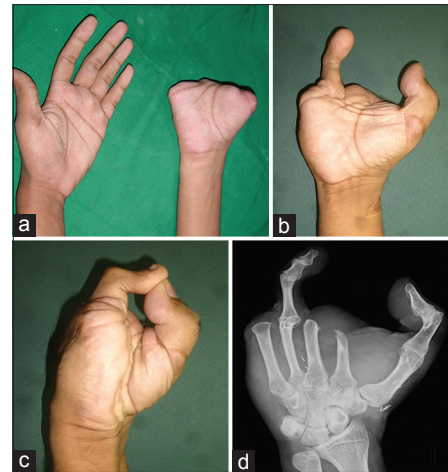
Patient 5, type 2A metacarpal hand. (a) Both hands, prior to toe transfer. (b) Right hand following great toe transfer to the thumb position and 2nd toe transfer to the ring finger position, showing maximum span and (c) full opposition. (d) Oblique radiograph 148 months following toe transfer showing bony union of both transfers
